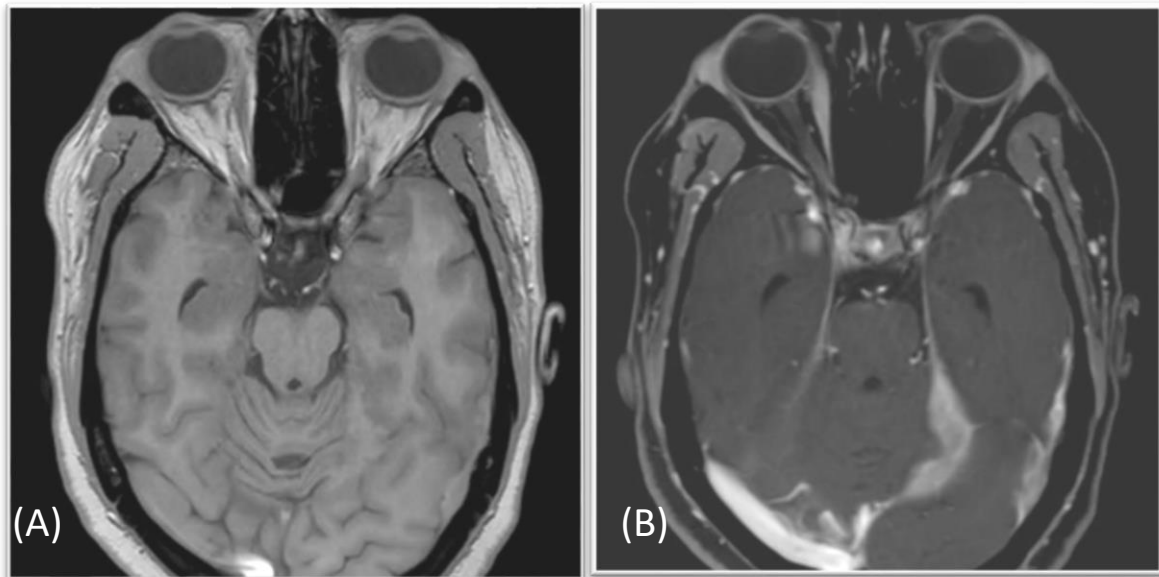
MRI Brain Plain (A) and contrast (B) showing bilateral enhanced and thickened meninges
